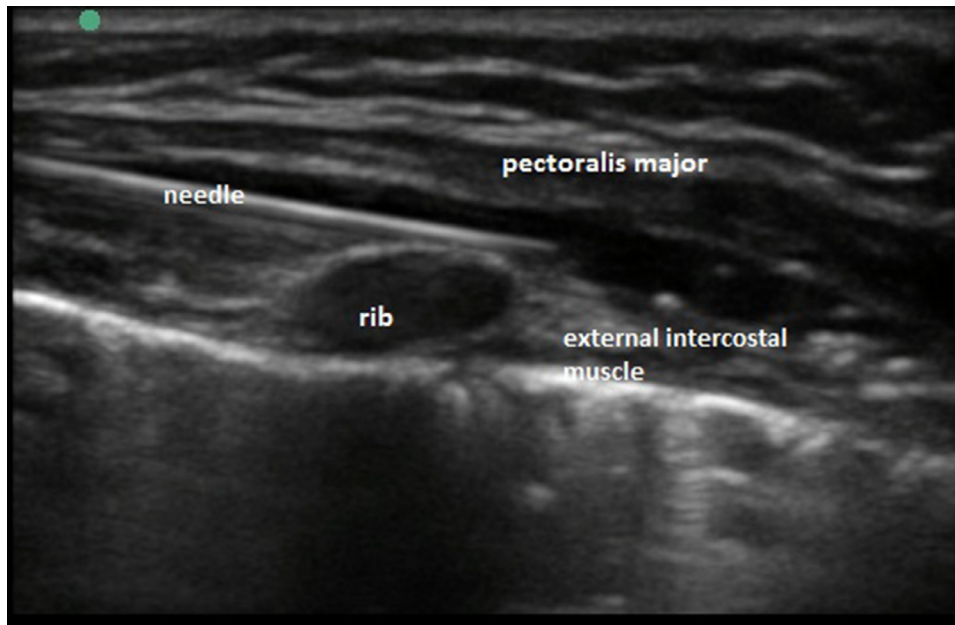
Ultrasound image showing needle placed between the pectoralis major and external intercostal muscle plane. Image also shows the rib shadow and underlying shiny pleura.
